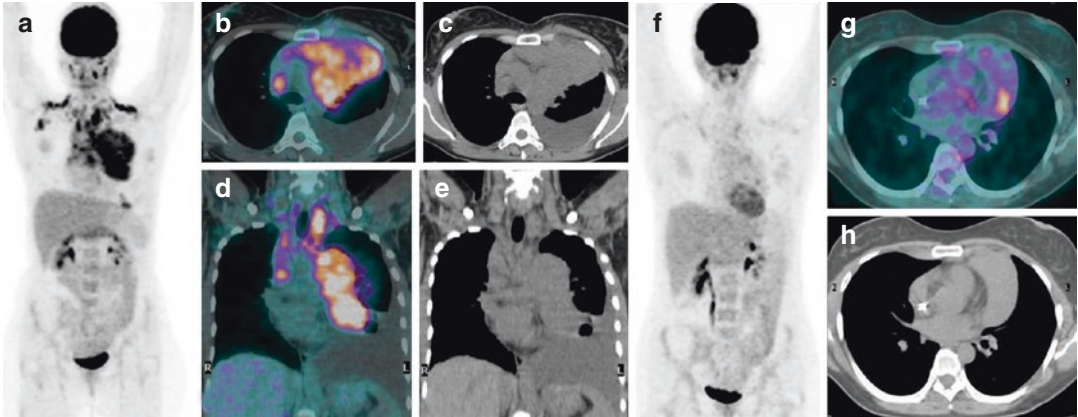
“Baseline (a–e) PET/CT” of a patient with Hodgkin lymphoma showing a bulky mediastinal mass with other cervical lymph nodes, expressing pathologic tracer uptake. Despite the significant reduction of the volume lesion after two cycles of *Adriamycin-Bleomycin-*
